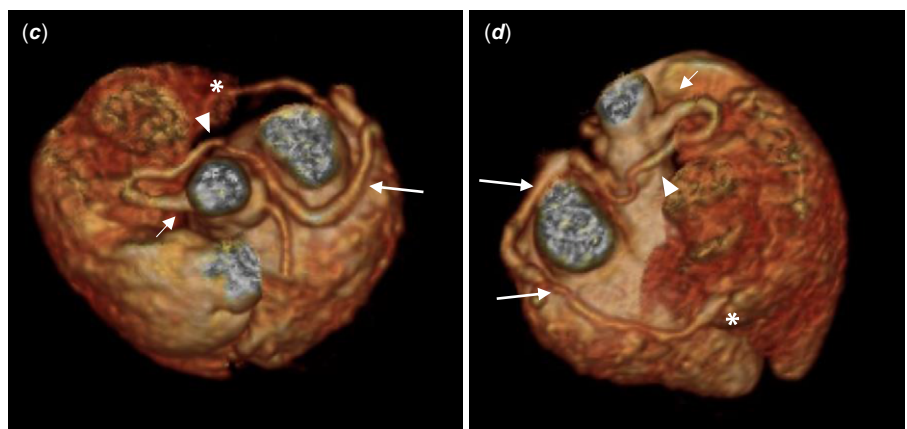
CT angiography 3D reconstructed images of the right coronary fistula to right ventricle: anteroposterior (c) and posteroanterior (d) views. Right coronary artery originated in the right coronary sinus (short arrows); retroaortic course (arrowheads) followed by a left atrioventricular groove course (long arrows); fistula in the right ventricle (*).
